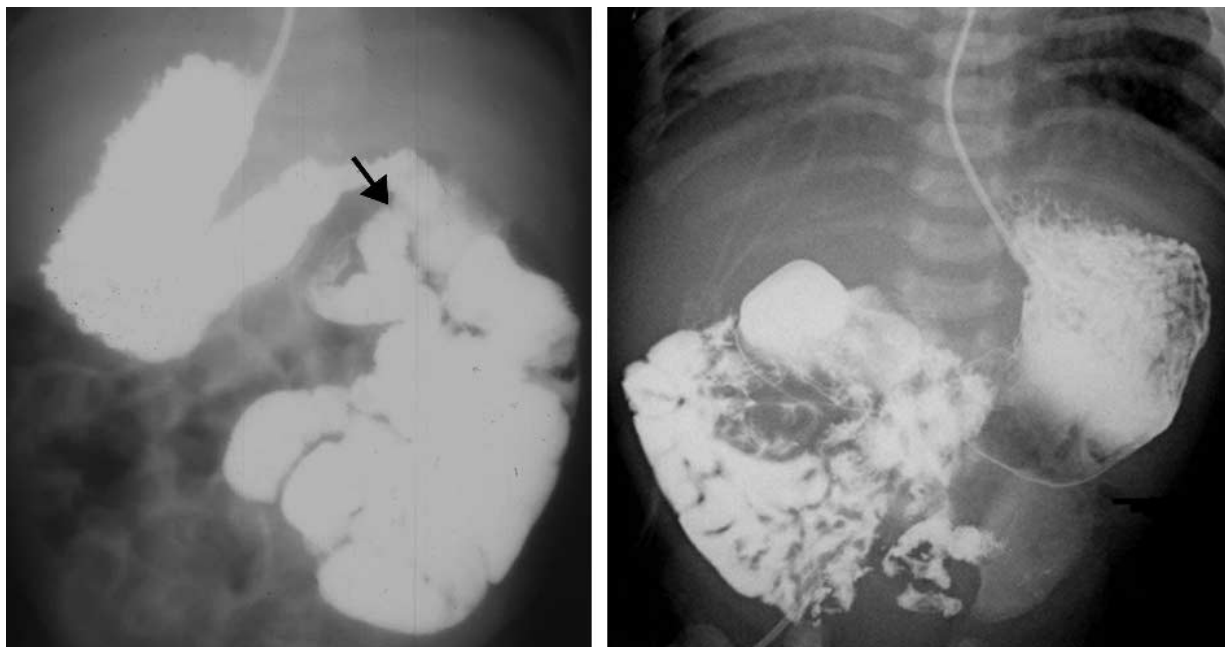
Malrotation in two infants with heterotaxy syndrome. (a) Radiograph from an upper GI series obtained with barium administered via a nasogastric tube shows a right-sided stomach, left-sided small bowel, and abnormal position of the duodenojejunal junction (arrow). (b) Radiograph in another infant shows a right-sided heart, left-sided barium-filled stomach, and right-sided barium-filled small bowel. The duodenojejunal junction (not shown) also was abnormally positioned.
